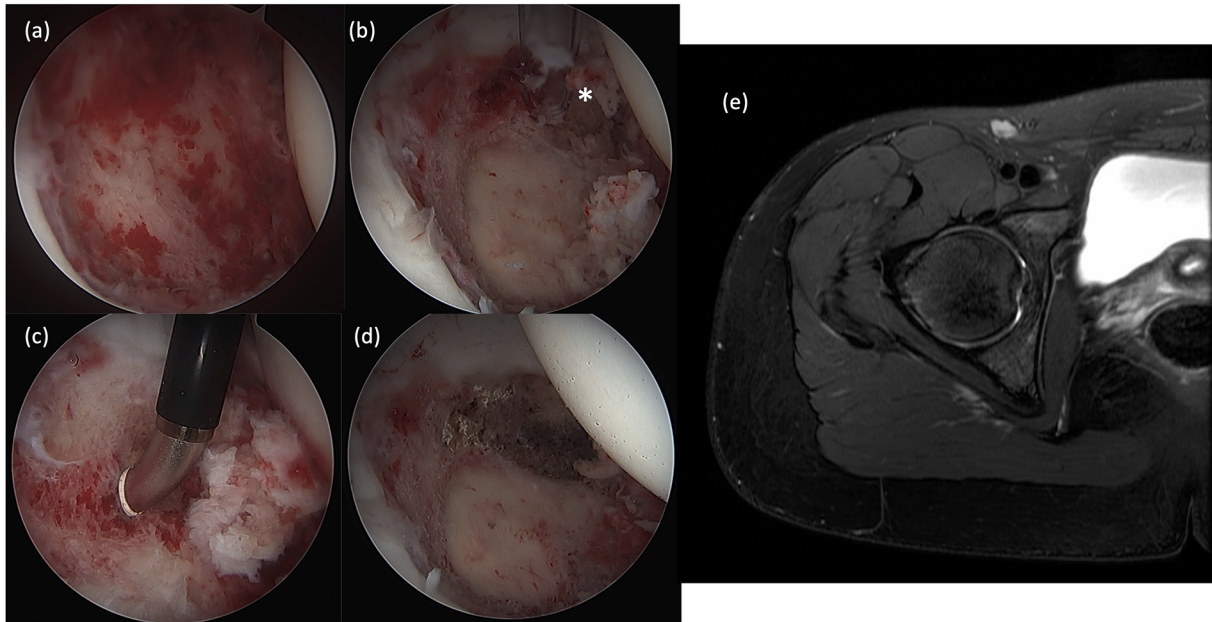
Intraoperative hip arthroscopy and postoperative MRI for Patient 3. In all intraoperative images, femoral head cartilage is visible on the right, with the acetabulum on the left. The anterior acetabulum is oriented at the top of the images. (a) View of the acetabular fossa upon initial inspection of the joint after clearing hemarthrosis. (b) View of acetabular fossa once the residual ligamentum teres was removed with a shaver with the exostosis marked by an asterisk. (c) Radiofrequency ablation of the body exostosis was performed with a curved, hip-length arthroscopic radiofrequency ablation device. (d) Articular surface of the acetabulum following curettage, burring, and radiofrequency ablation of the bony exostosis. (e) Postoperative MRI at the 7-month interval with resolution of the previously seen bone marrow edema and synovitis.
